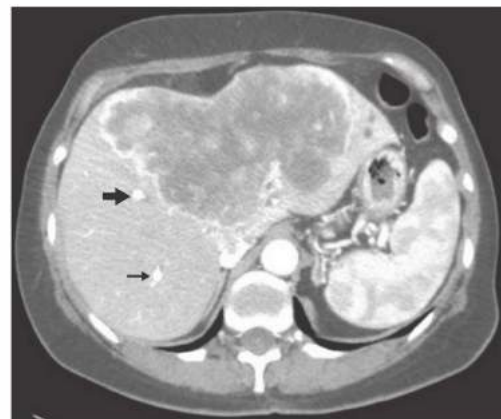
• Triple-phase CT scan (portal venous phase) of a cholangiocarcinoma involving segments 1, 2, 3, 4, 5, and 8. The right anterior (*thick arrow*) and posterior (*thin arrow*) pedicles are visible. This patient underwent left trisectionectomy with excision of the caudate lobe, which resulted in R0 excision of the tumor and a favorable outcome.
